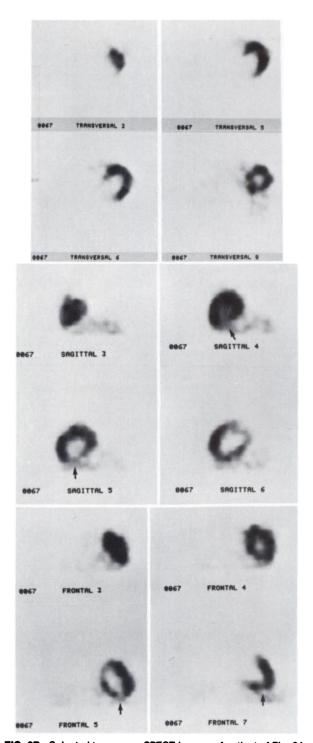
Selected transverse SPECT images of patient of Fig. 2A, with no defects (upper). Contiguous series of sagittal slices (3–6) (center) showing decreased uptake in inferior portion of posterior wall (arrows). Confirmation of defect (lower) in frontal cuts (arrow). Computer-processed image (isocount plot) of 90° LL projection, with decrease in apical region (arrow).
